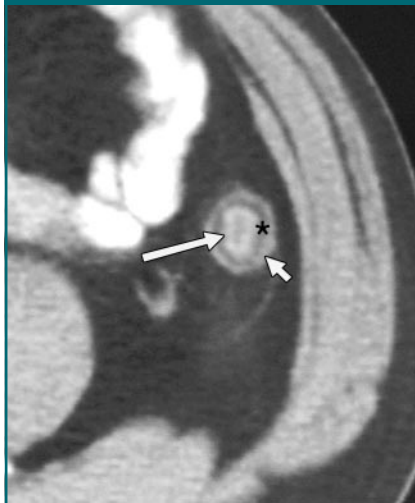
Fat halo sign in ulcerative colitis. Transverse CT scan shows the central fatty submucosal layer of low attenuation (*) surrounded by higher-attenuation inner (long arrow) and outer (short arrow) layers grossly corresponding to the mucosa and muscularis propria and serosa of the descending colon, respectively.
